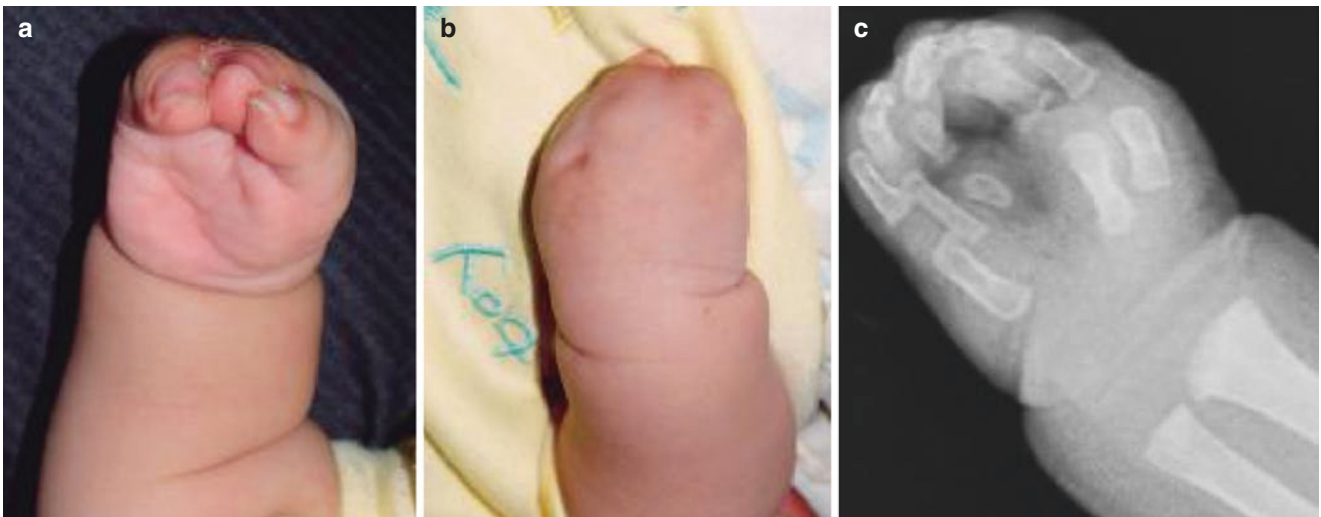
Spade hand deformity. (a, b) Hand appearance. (c) X-ray findings
